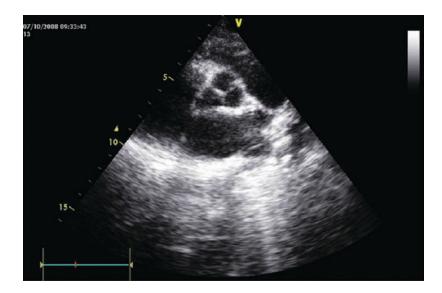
Parasternal short-axis view at the level of the aortic valve ("Mercedes sign" in diastole) and right ventricle
